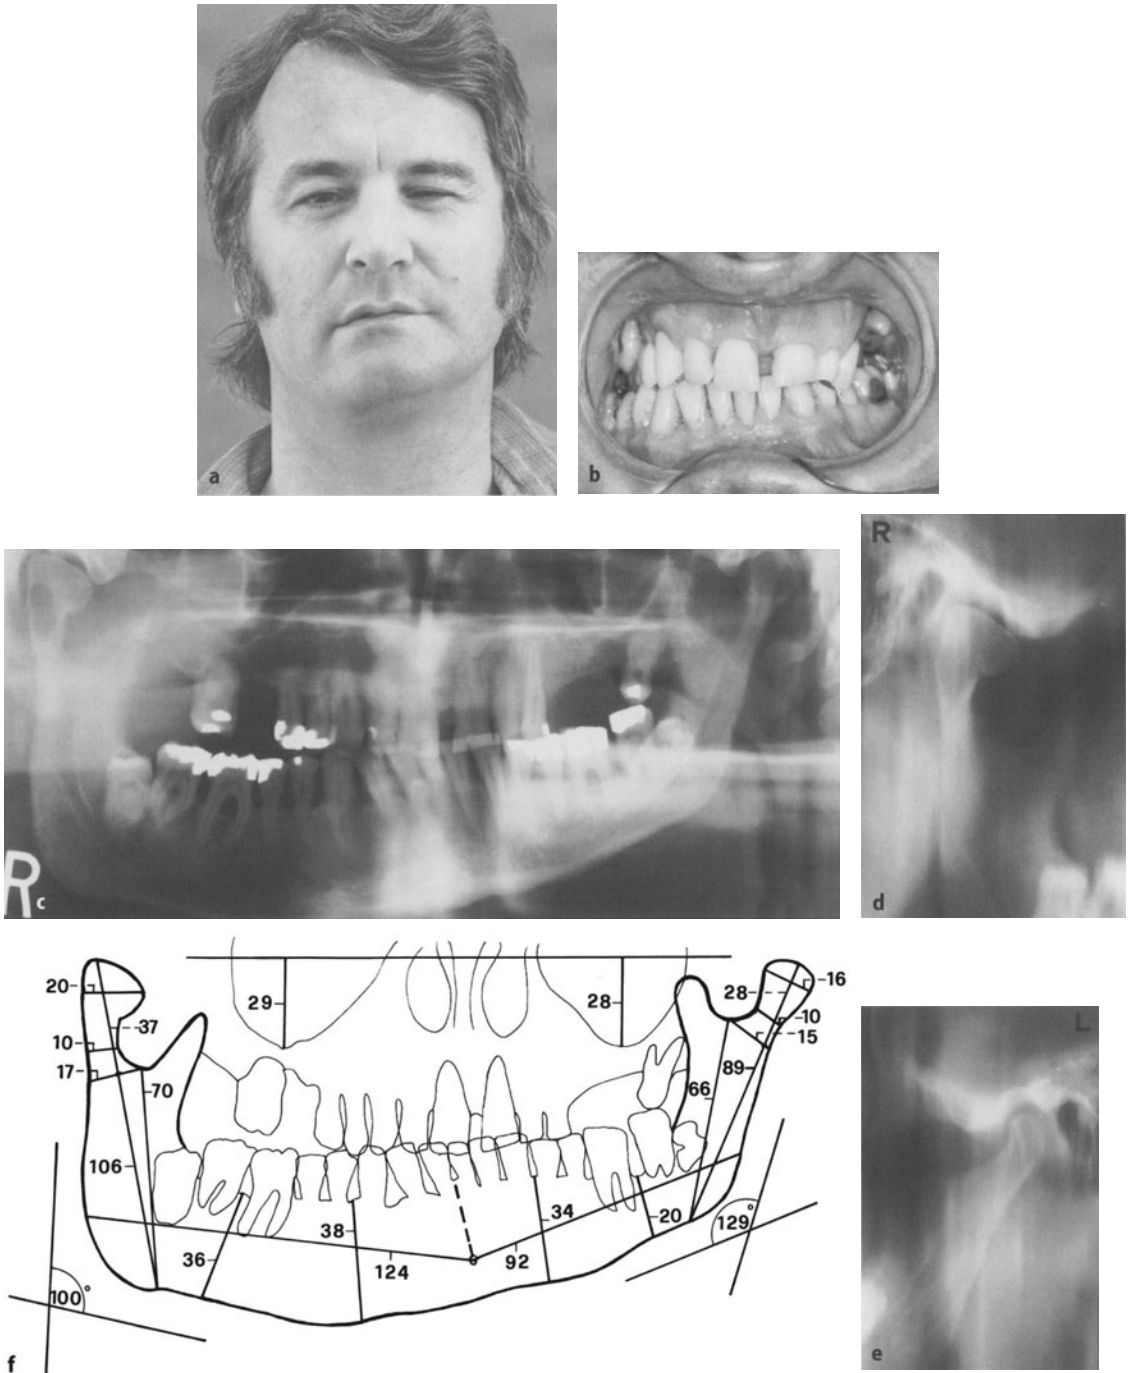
Unilateral H.H. with a tumour-like enlargement of the upper half of the condyle, which started at age 42. a Patient's appearance in front view showing the typical facial disfigurement due to H.H. of the right side. b The occlusal photograph does not show a very clear situation due to the poor dentition except that the teeth on the side of the H.H. seem longer than those on the other side. c The panoramic view is very interesting as it raises the question whether or not the unilateral elongation of the right ascending ramus is due to a tumour of the condyle or not. d, e The TMJ ramus tomograms do not answer that question clearly, except for the fact that the enlargement of the right condyle would not permit a clear diagnosis of the type of tumour. f The measurement evaluations of the tracing of the panoramic radiograph eliminate all doubts
